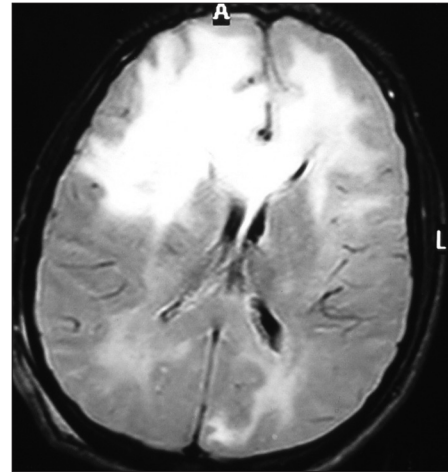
Magnetic resonance imaging of the brain showing hyperintensities on T2 flair image in bilateral frontal regions, predominantly involving white matter including corpus callosum as well as parietooccipital area to some extent
